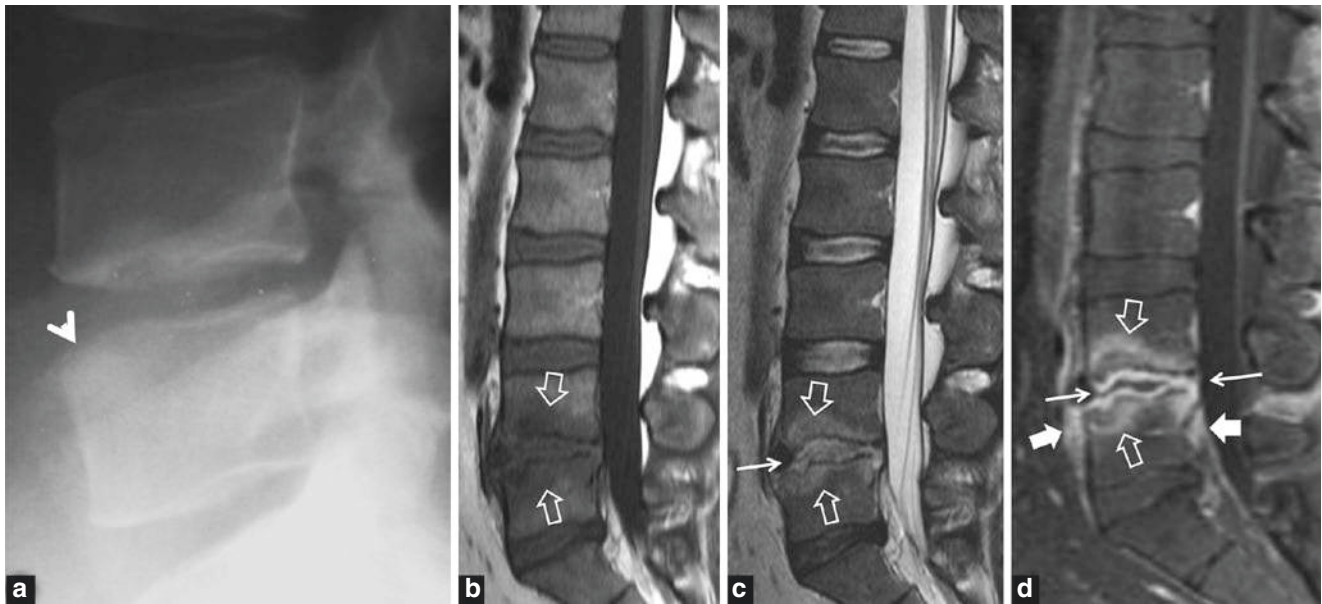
34-year-old male patient with 2 months of low back pain without sciatica and a final diagnosis of *Brucella* spondylodiscitis. Lateral radiograph (a) shows indistinct anterior superior endplate of L5 vertebral body (arrowhead) and subcortical sclerosis. Sagittal T1 (b), T2 (c)
